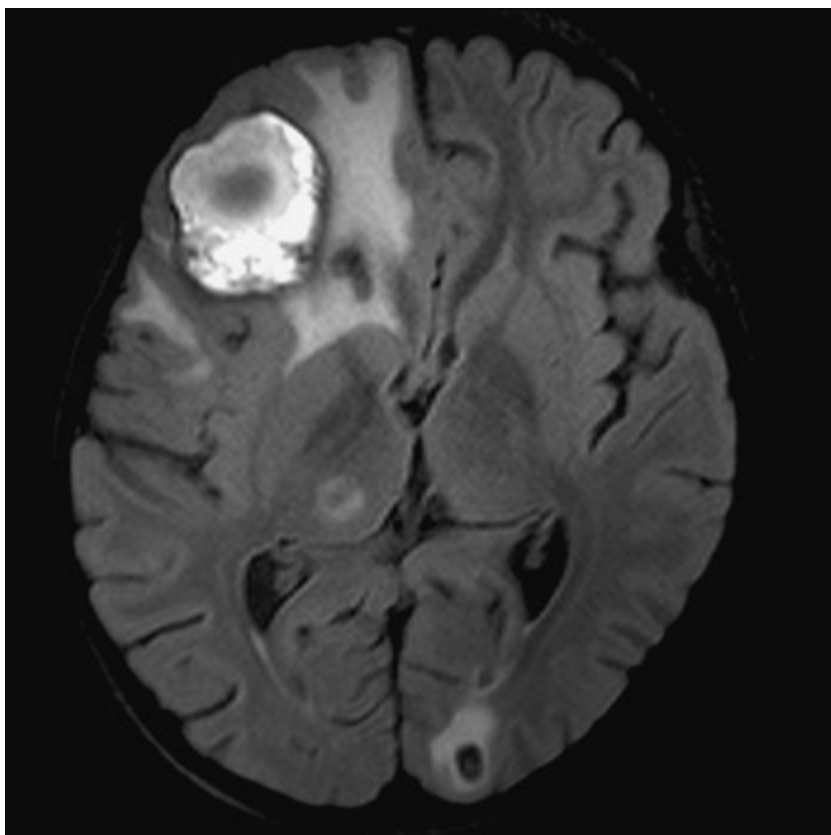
Axial 3D water excitation FLAIR image of the same patient in Figure 15.3.
